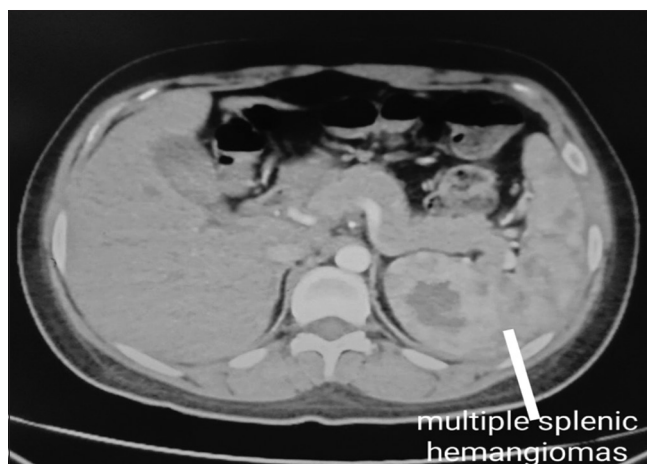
Contrast enhanced computed tomography scan showing splenomegaly with multiple isodense lesions with centripetal enhancement (periphery to center) suggestive of hemangiomas
